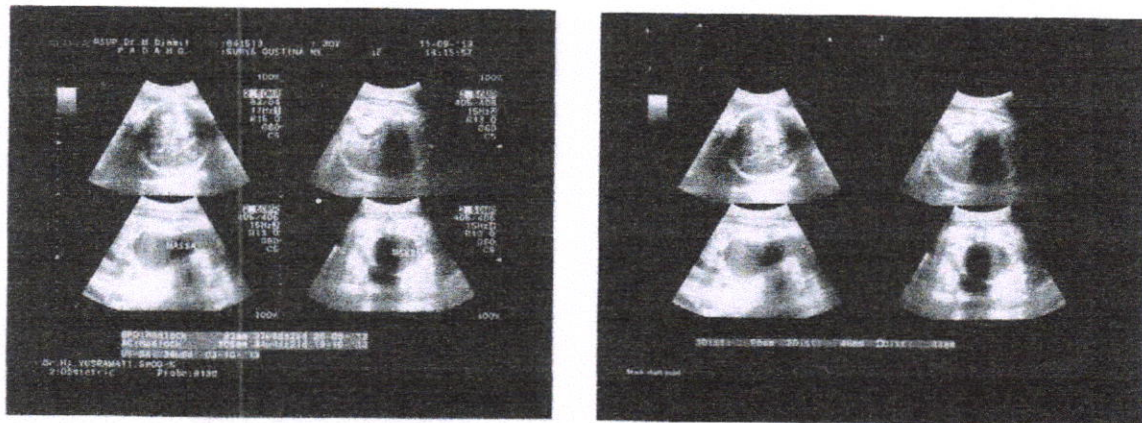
IntraUterin Ultrasounds
